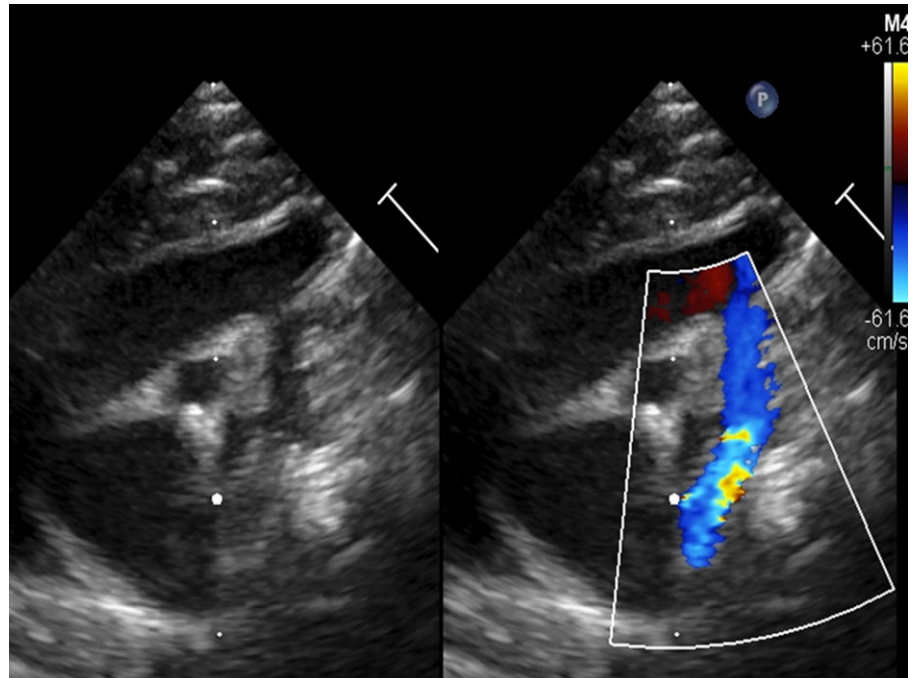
Movie 2: post-procedural echocardiography showing a well apposed coronary stent with coarctation relief.
